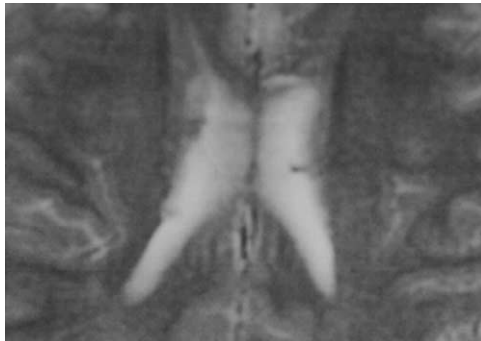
Axial T2-weighted MRI demonstrating the same subependymal nodules as in Figure 8.
